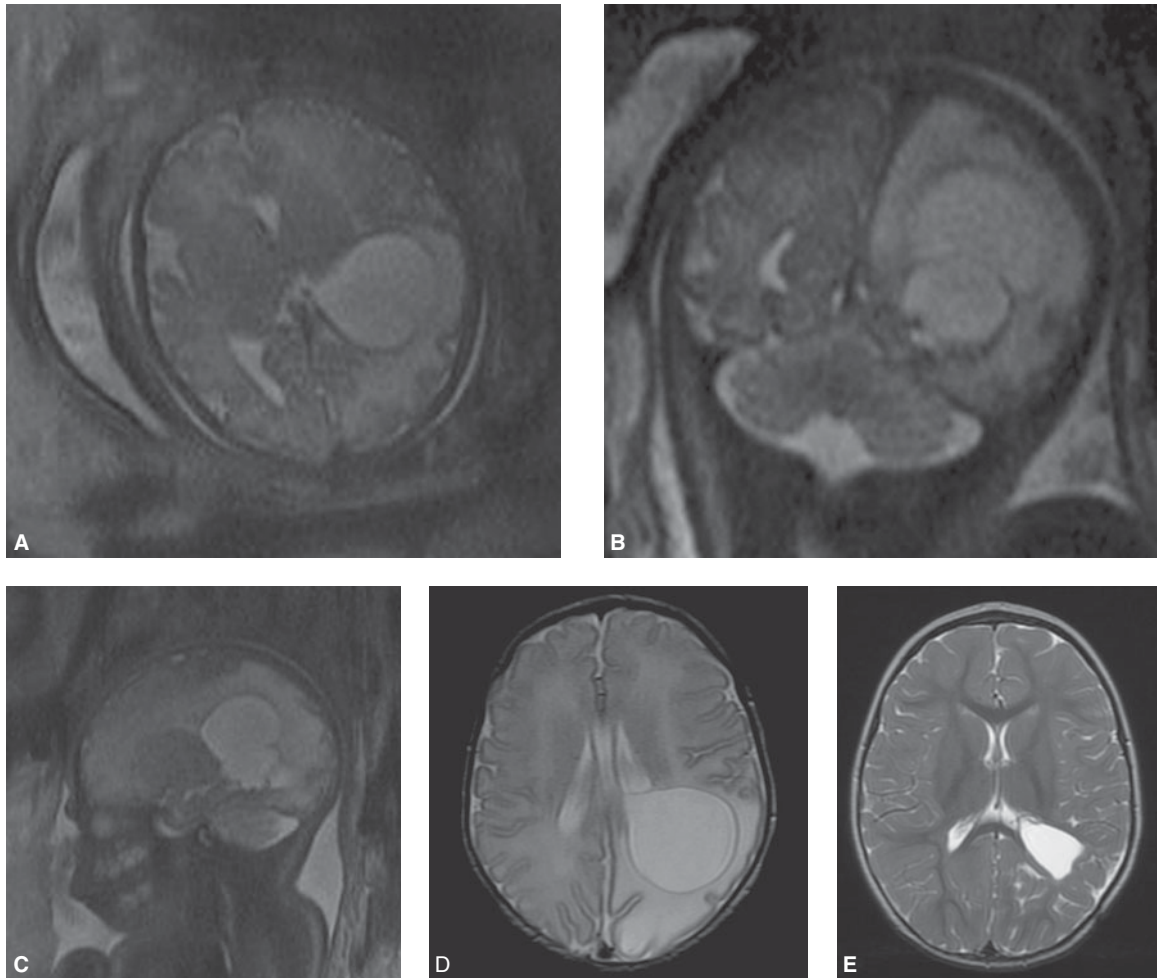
Prenatal and postnatal magnetic resonance imaging (MRI) in a patient with lateral ventricle choroid plexus papilloma (CPP; same patient as in Figure 13-14). Axial (A), coronal (B), and paramedian (C) planes at 36 weeks of gestation show the large, predominantly cystic tumor and the abnormal surrounding brain parenchyma. (D) Axial plane at the age of 9 days. (E) Same plane at 15 months of age following surgical resection of the tumor. Normal neurologic and developmental follow-up was done at 3 years of age. (Courtesy of Liat Ben Sira, MD, Tel Aviv, Israel.)
